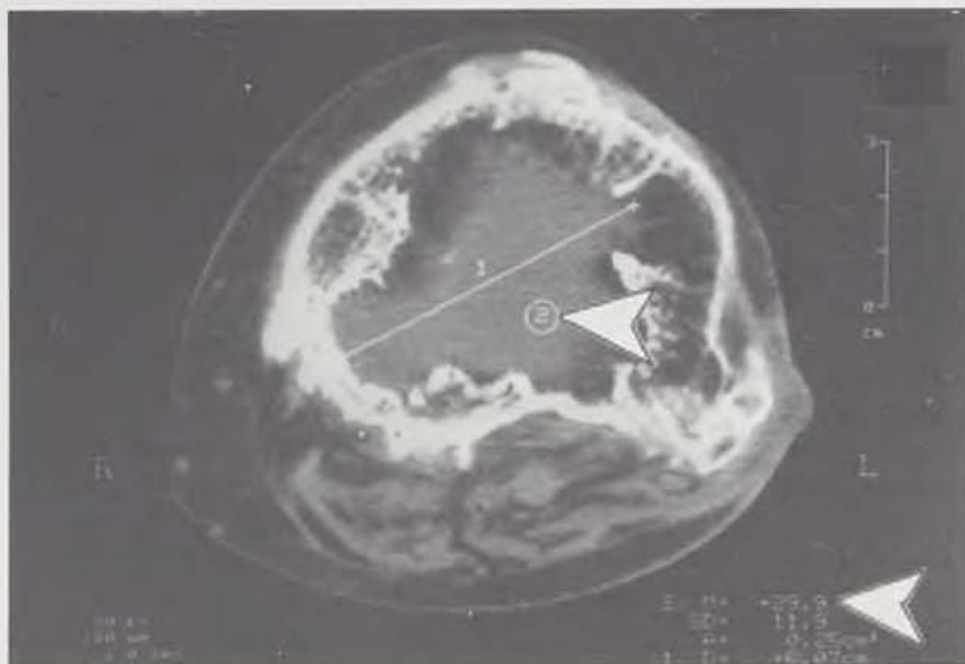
CT check 23 months after free flap transfer - area beneath tibial plateau filled with granulation tissue
